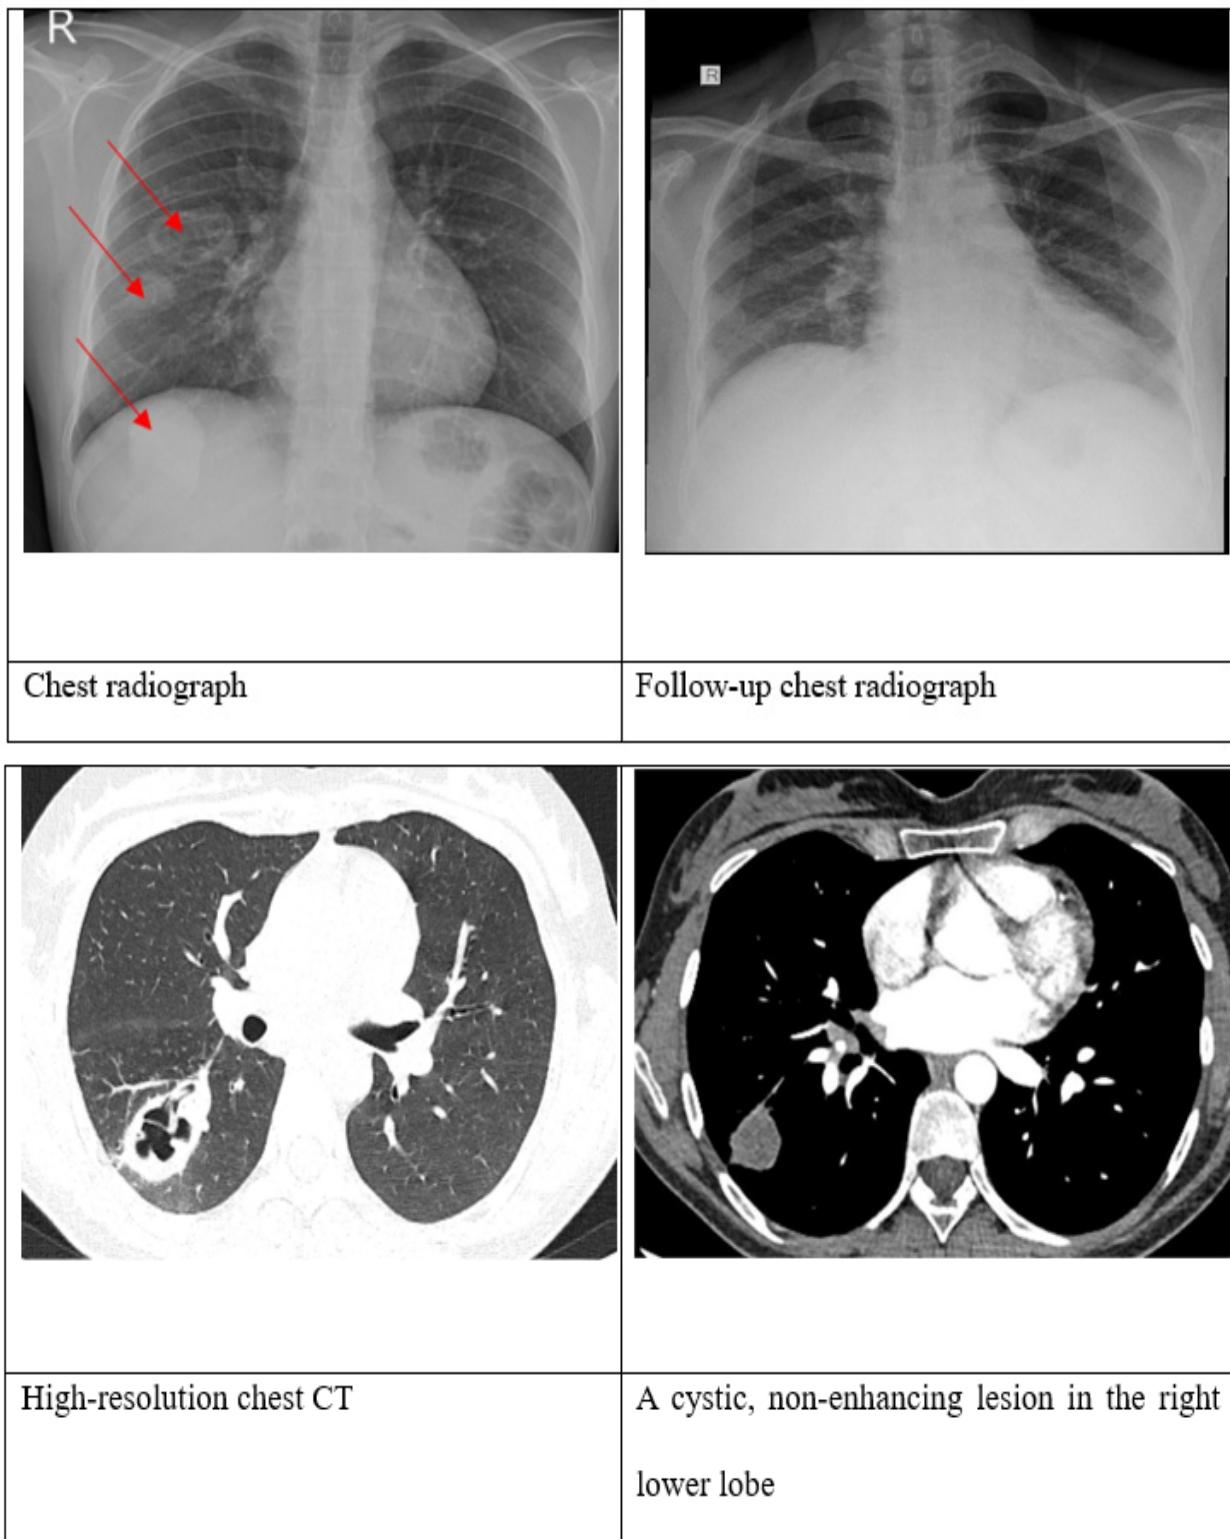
Radiograph and CT findings of the patient
